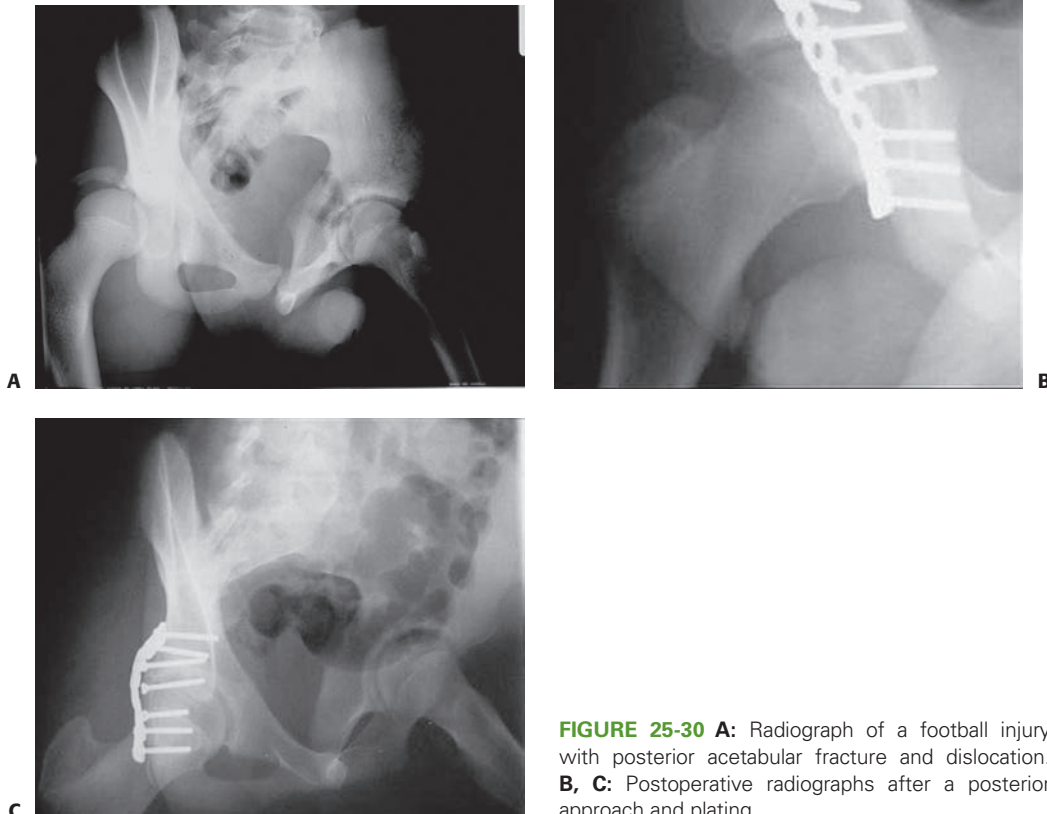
A: Radiograph of a football injury with posterior acetabular fracture and dislocation. B, C: Postoperative radiographs after a posterior approach and plating.
